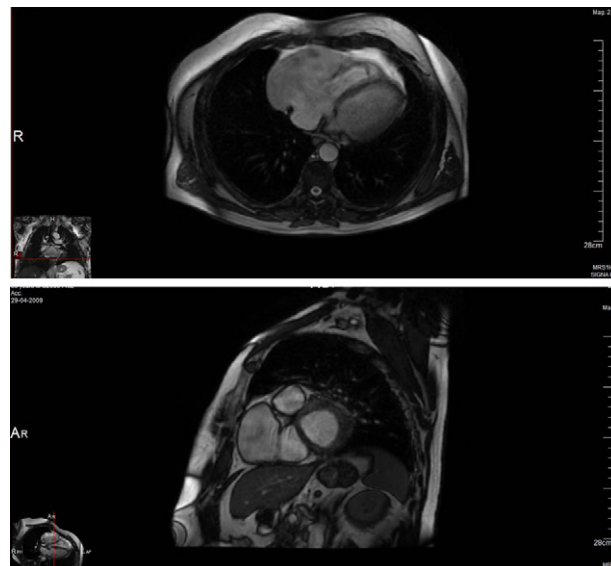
Cardiac magnetic resonance imaging (FIESTA), showing an anterior aneurysmal cavity in the right atrial free wall (11.2 cm × 6.6 cm) in right ventricular long-axis view (top) and in transverse view (bottom).
